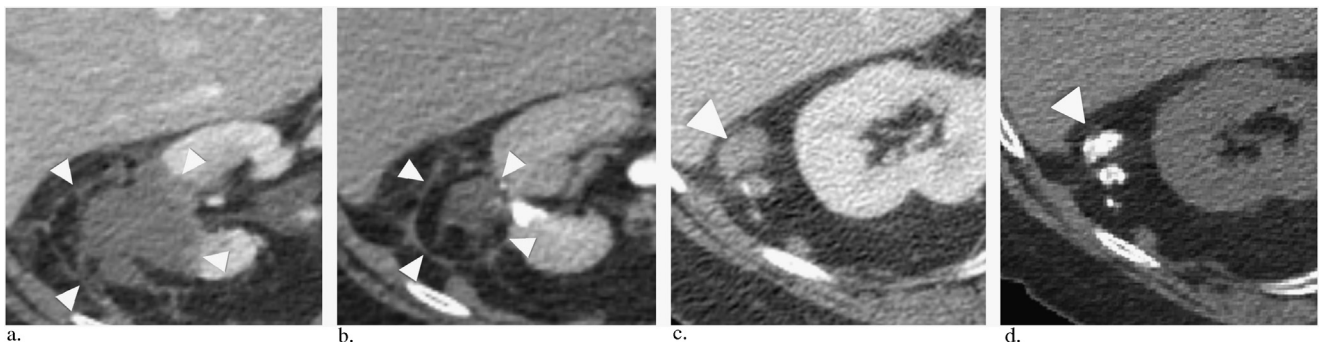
Follow-up contrast-enhanced axial CT imaging in patient 1. (a) At 1 month after ablation, no enhancement was seen in the renal ablation zone, and there was perinephric soft-tissue stranding and an emerging perinephric soft-tissue halo (arrowheads). (b) At 12 months after ablation, a smaller renal ablation zone was seen, with no evidence of tumor recurrence and a more defined perinephric soft-tissue halo (arrowheads delineate halo). (c) At 26 months after ablation, new, enhancing, and partially calcified nodular soft-tissue densities had appeared at the edge of the ablation zone in the perinephric fat (arrowhead). The largest nodule is indicated with an arrowhead. (d) At 32 months after ablation, there is near-complete calcification of the perinephric nodules (arrowhead).
